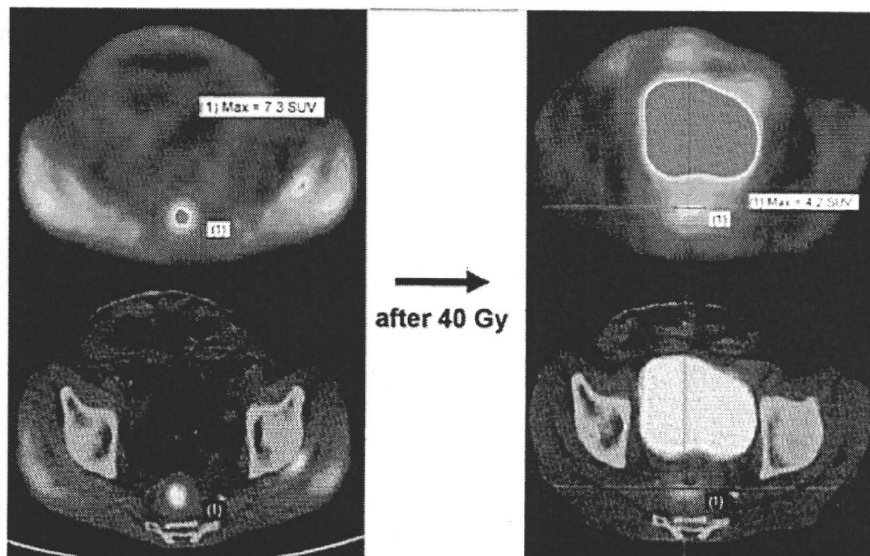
Change in FDG accumulation. This patient had anastomotic recurrence with 7.3 SUVmax before radiation therapy. After 40 Gy, the accumulation was decreased by 3.1 SUVmax.
